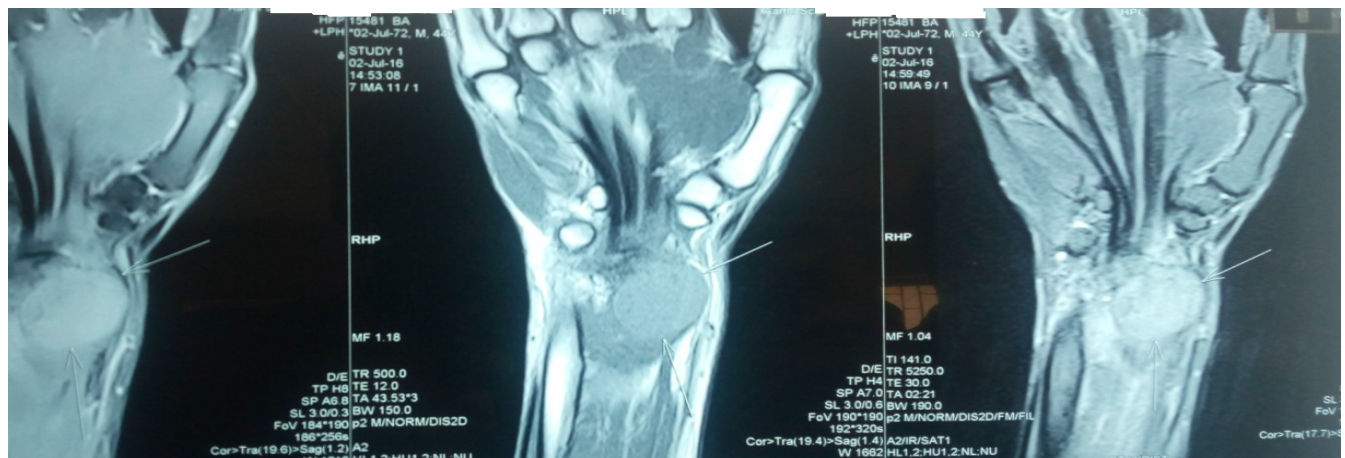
T1 and T2-weighted magnetic resonance imaging of right distal radius shows features suggestive of giant cell tumor.
